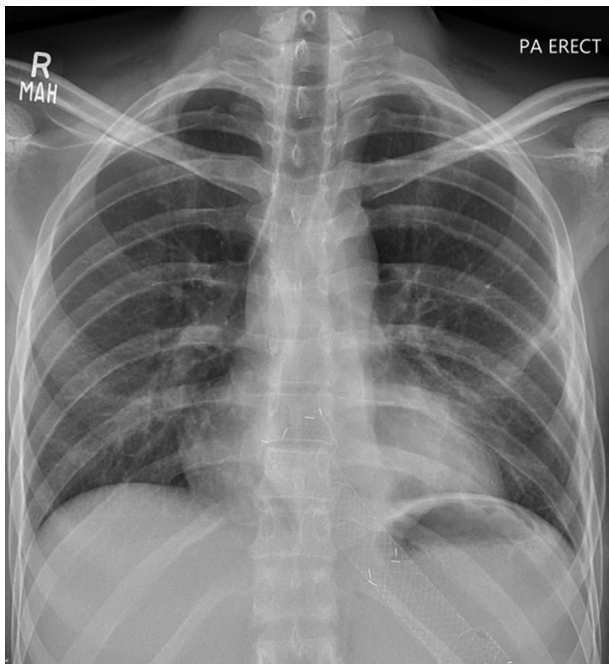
Post-treatment, a 3-month follow-up shows a normal chest radiograph.
